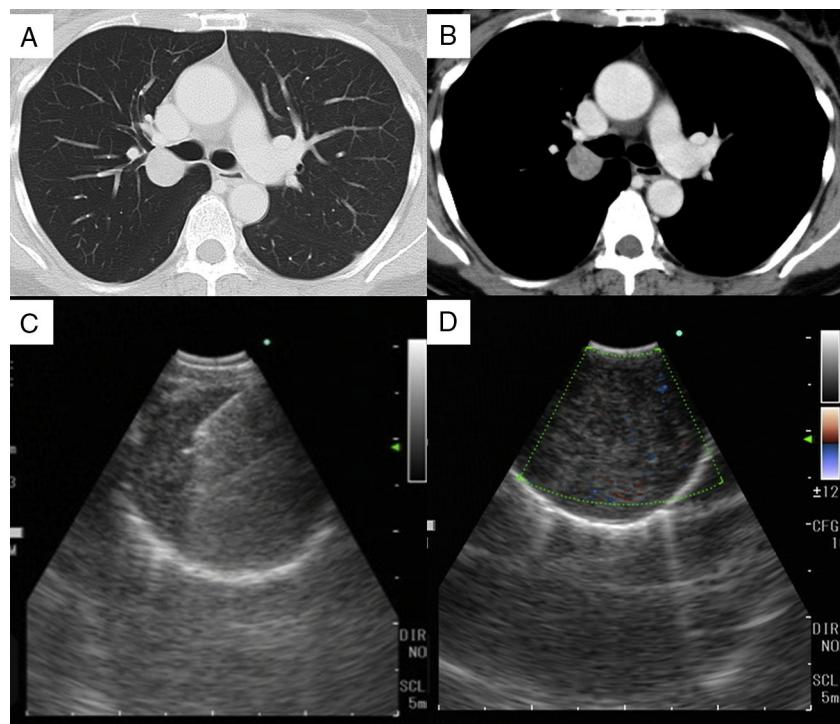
Chest CT revealed a round, well-defined 2.4-cm nodule in S2, adjacent to the right upper lobe bronchus (A, B). EBUS showed a well-defined hypoechoic tumor, with an echogenic capsule and posterior acoustic enhancement (C, D).
